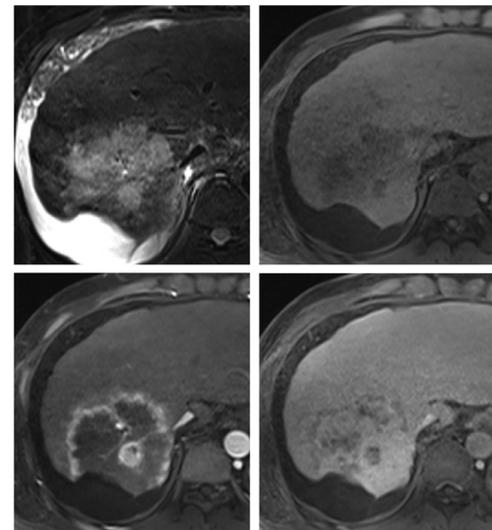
Parenchymal type CCA in a 40-year-old man with B-viral cirrhosis. A, B. The irregularly margined mass is hyperintense on the T2-weighted fast spin-echo image (A) and hypointense on the T1-weighted 3D fat-suppressed gradient-echo image (B). C, D. The dynamic arterial (C) and delayed (D) phase images show irregular peripheral enhancement and delayed central enhancement. Note that there is no biliary dilation in either the peritumoral or remote areas of the liver even though the mass is relatively large.
